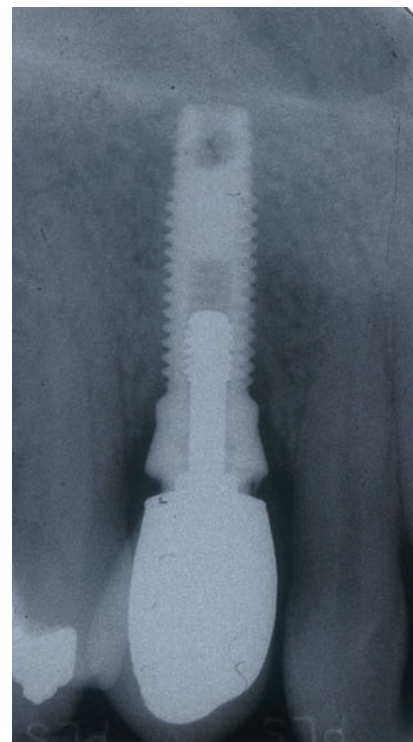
A radiograph of a gap between abutment and crown. Failure to seat the crown may be due to hydrostatic pressure between a parallel abutment and the close fit of the crown, or premature setting of the cement, or a problem has arisen through recording of the position of the abutment during the impression process.
